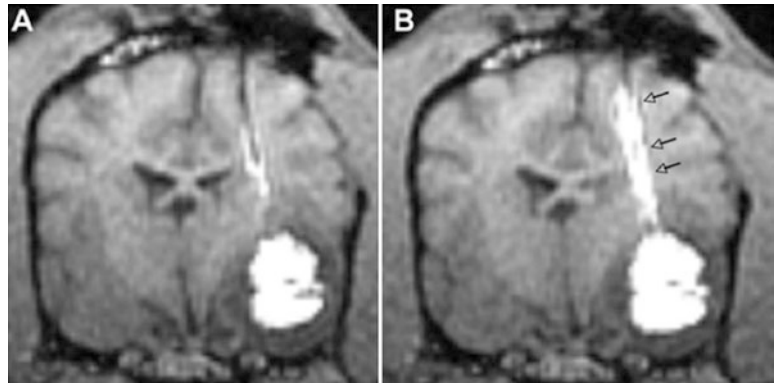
MRI of CED with and without significant reflux. Low reflux along the path of the cannula at 5 $\mu\text{L}/\text{min}$ (a) and high reflux at 8 $\mu\text{L}/\text{min}$ (b) as indicated by arrows. (Modified from ref. [53] with permission)
